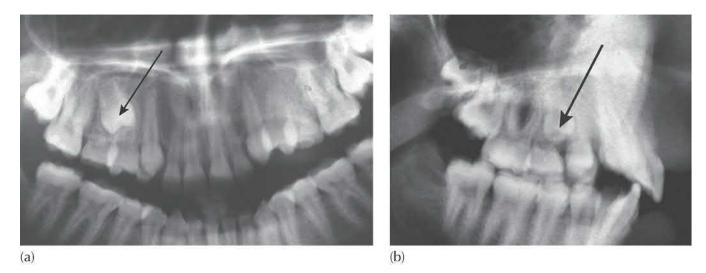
The lateral tube shift method using a panoramic radiograph and a lateral cephalogram. (a) In the panoramic view, the X-ray cone projects this image in the premolar area when it is behind the ear of the opposite side and therefore provides an oblique lateral view. This gives the misleading impression that the unerupted right second premolar (arrow) is rotated. (b) The lateral cephalometric view of the same patient shows only a very mild mesial displacement of the second premolar (arrow), with a minimal rotation of its palatal cusp in a mesial direction. Since this projection is a true lateral view, this is the true mesio-distal position of the tooth. The imaging of the second premolar for a panoramic view is made when the X-ray cone is behind the ear on the other side. This means that the apparent mesial displacement and apparent rotation of the tooth, seen here, confirm that it is also palatally displaced. Its size relative to the first premolar also confirms its palatal displacement. A tooth placed palatally vis-à-vis the focal trough appears wider than the same tooth in a buccal position.
